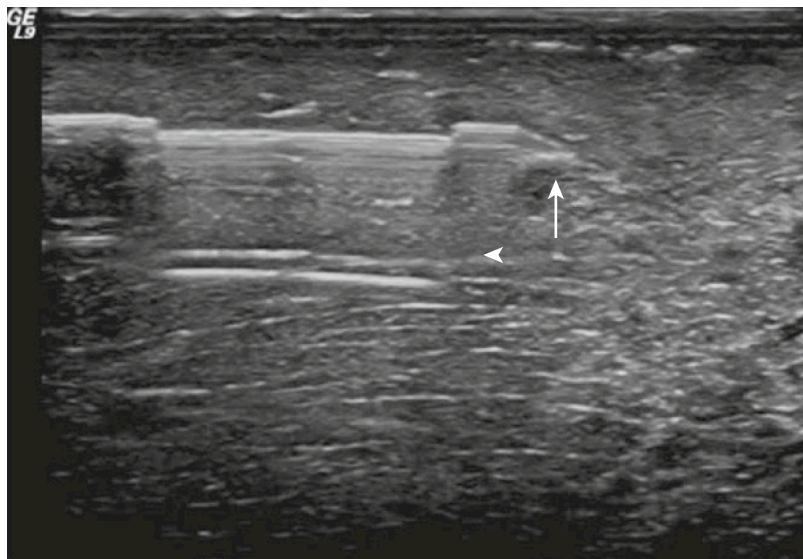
In an ultrasound-guided biopsy, the Tru-Cut biopsy needle (*arrow*) can be seen in the muscle. It is parallel to the long axis of the transducer and causes strong reverberation artifacts (*arrowhead*).
